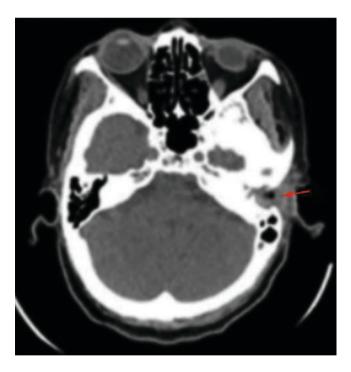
Axis CT of temporal bone demonstrates carcinoma of the left auditory meatus (arrow), with slight bone destruction of the external auditory
